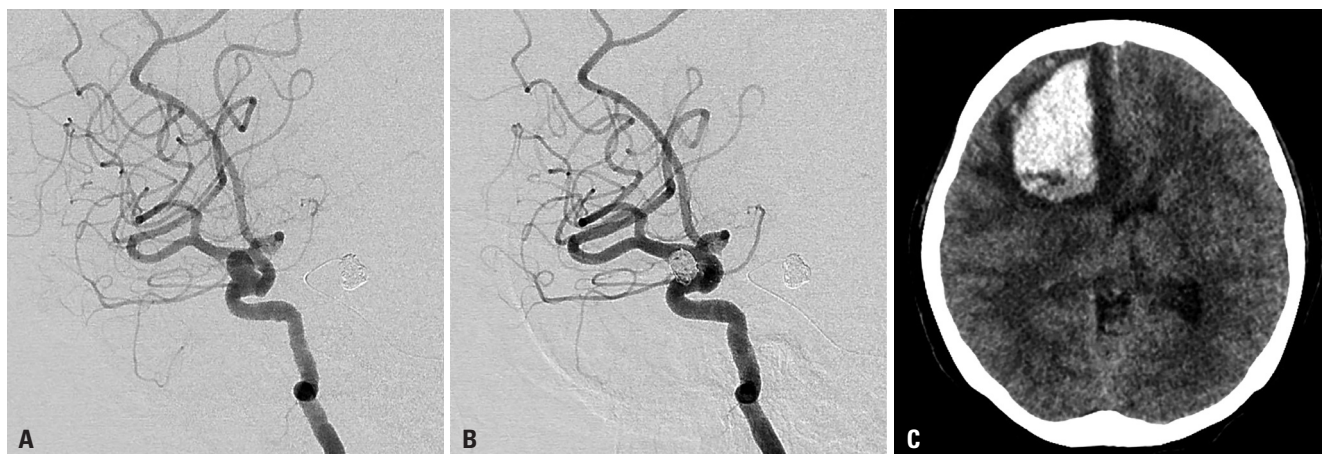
(A and B) Right ICA angiographies before and after endovascular treatment showing another aneurysm located on the right paraclinoid ICA and uneventful stent-assisted coiling. (C) Non-contrast computed tomography showing a right frontal hematoma. ICA: internal carotid artery.
